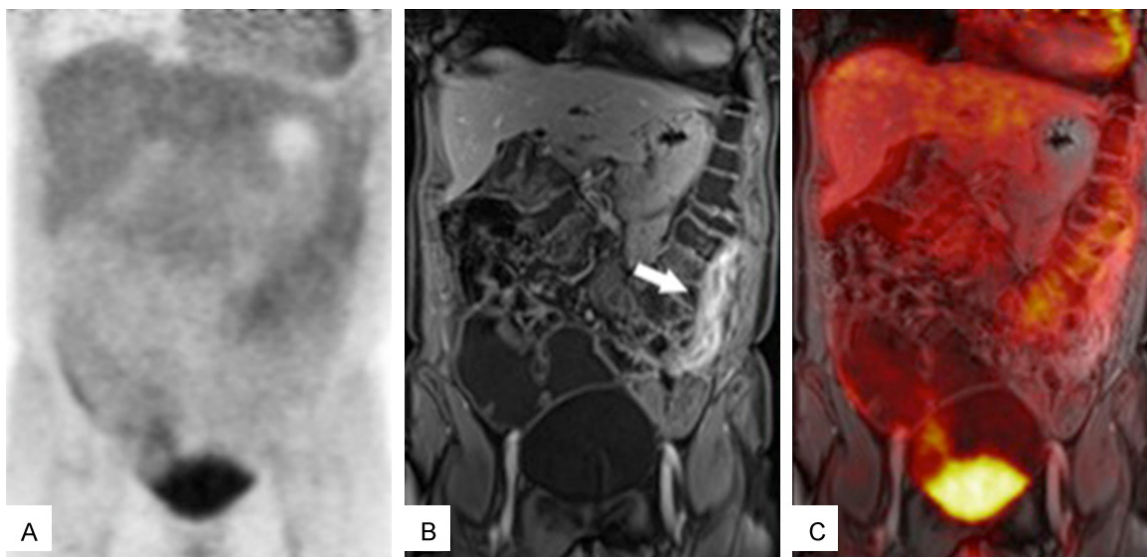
False positive MR case. Coronal PET (A), coronal CE-VIBE (B), and fused PET/MR (C). A segment of bowel wall thickening with abnormal hyperenhancement was identified in the left lower quadrant of the abdomen on MR (arrow). However, no FDG uptake in this region was detected on PET. Additionally, no active bowel inflammation was observed during surgery.
